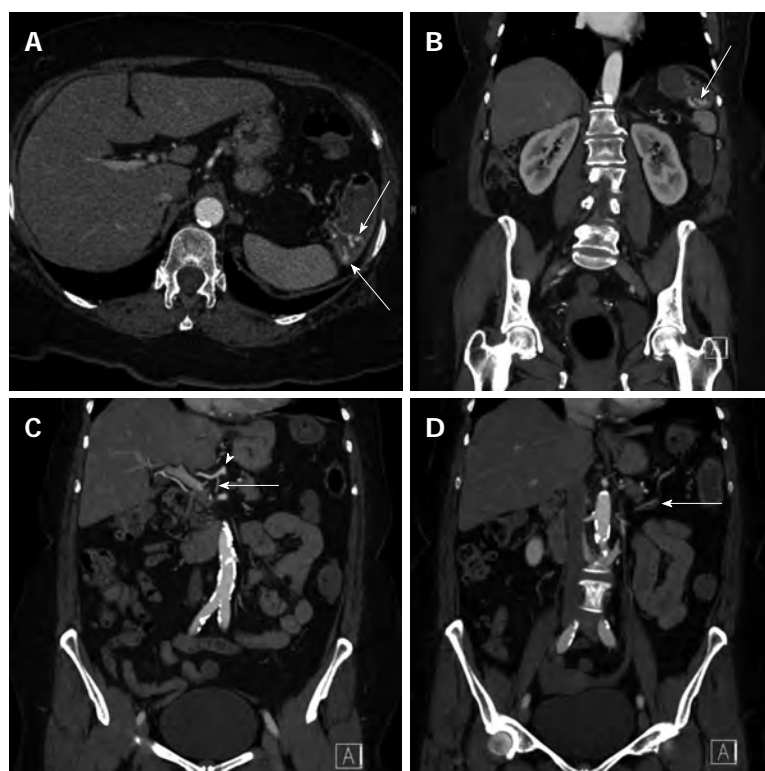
Computed tomography angiography with arterial phase (20 s following injection) acquisition. A, B: Axial image (A) and coronal images (B) demonstrating active contrast extravasation (arrows) at the splenic flexure; C: Coronal reformatted image demonstrating a celio-mesenteric branch (arrow) arising from the common hepatic artery (arrowhead); D: Seen in the large bowel mesentery (arrow) and supplying the splenic flexure.
